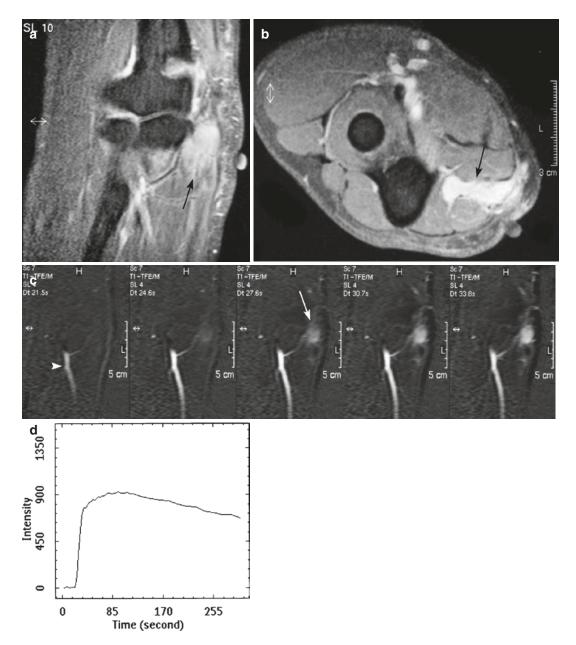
(a–d) Fifteen months after resection and radiotherapy of a liposarcoma of the elbow in a 25-year-old male: (a, b) coronal and axial fat-suppressed T1-weighted MR image after gadolinium chelate shows an ill-defined homogeneous enhancing soft tissue mass (*arrow*). Markers on the skin demonstrate the surgical scar; (c) coronal consecutive dynamic contrast-enhanced subtraction images of the same level obtained with a temporal
